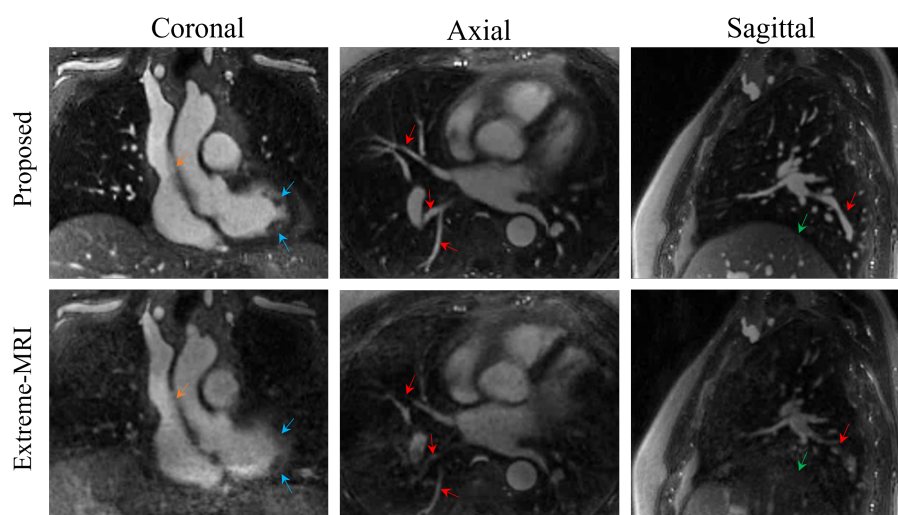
Visual comparison between the proposed reconstruction and Extreme-MRI reconstruction. The comparison is based on one slice of end-diastolic phase from one of the subjects. From the figure, we can see that the proposed method is able to catch more details about vascular (highlighted by the red arrows). Also, we can see that the proposed method is able to catch tiny structures such as coronary (highlighted by the orange arrows) and the papillary muscle (highlighted by blue arrows). Also, we can see that the liver-lung interface are shown more clear in the proposed reconstruction (highlighted by green arrows).
